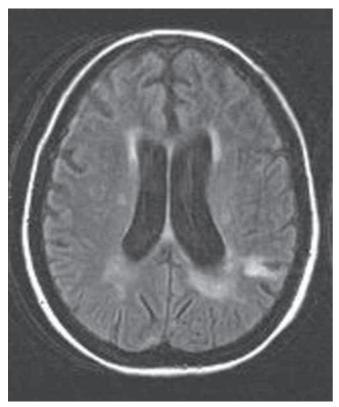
Brain MRI-T2/FLAIR after two weeks of treatment.
